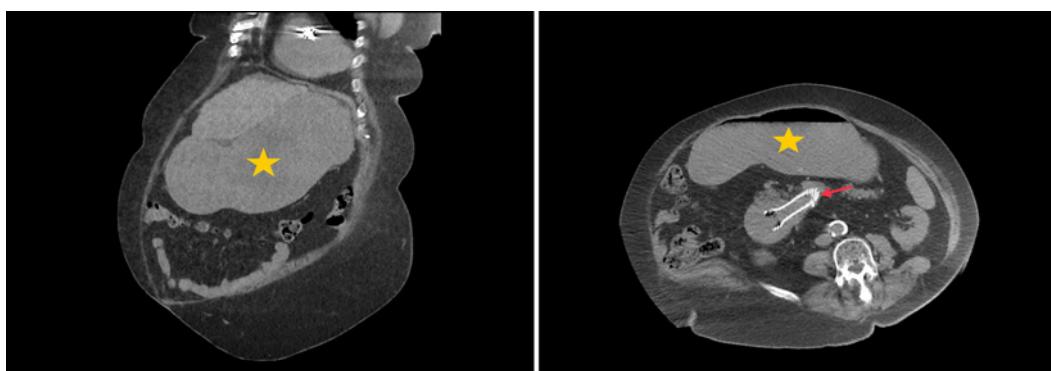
A CT scan of the abdomen and pelvis (coronal and axial views) showing significant distension of the stomach and proximal duodenum. A duodenal stent (red arrow) can be seen in the horizontal portion of the duodenum.
